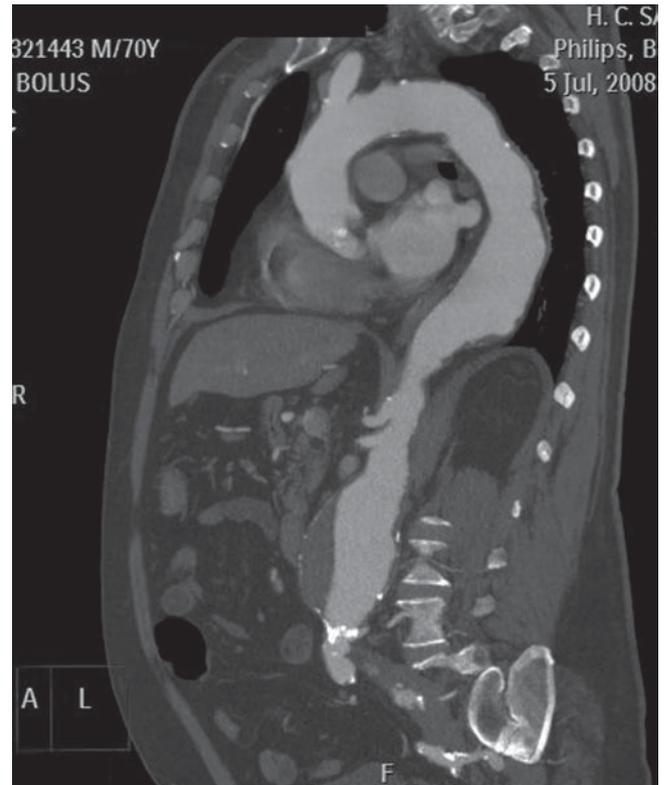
Sixty-four-rows multi-slice CT of a patient with combined thoracic and abdominal aneurysms. This finding is relatively frequent because of the critical importance of the atherosclerosis in the origin of them in contrast with ascending aortic aneurysm in which cystic degeneration plays an important role
